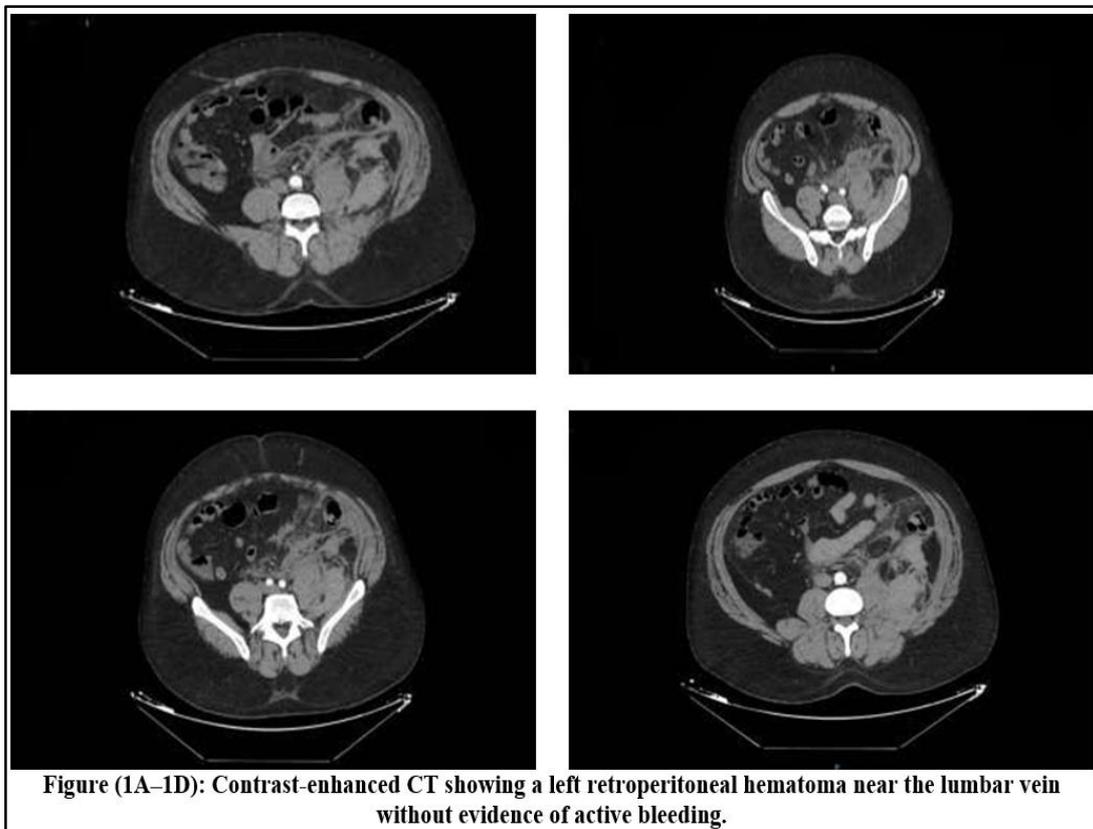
1D): Contrast-enhanced CT showing a left retroperitoneal hematoma near the lumbar vein without evidence of active bleeding.
